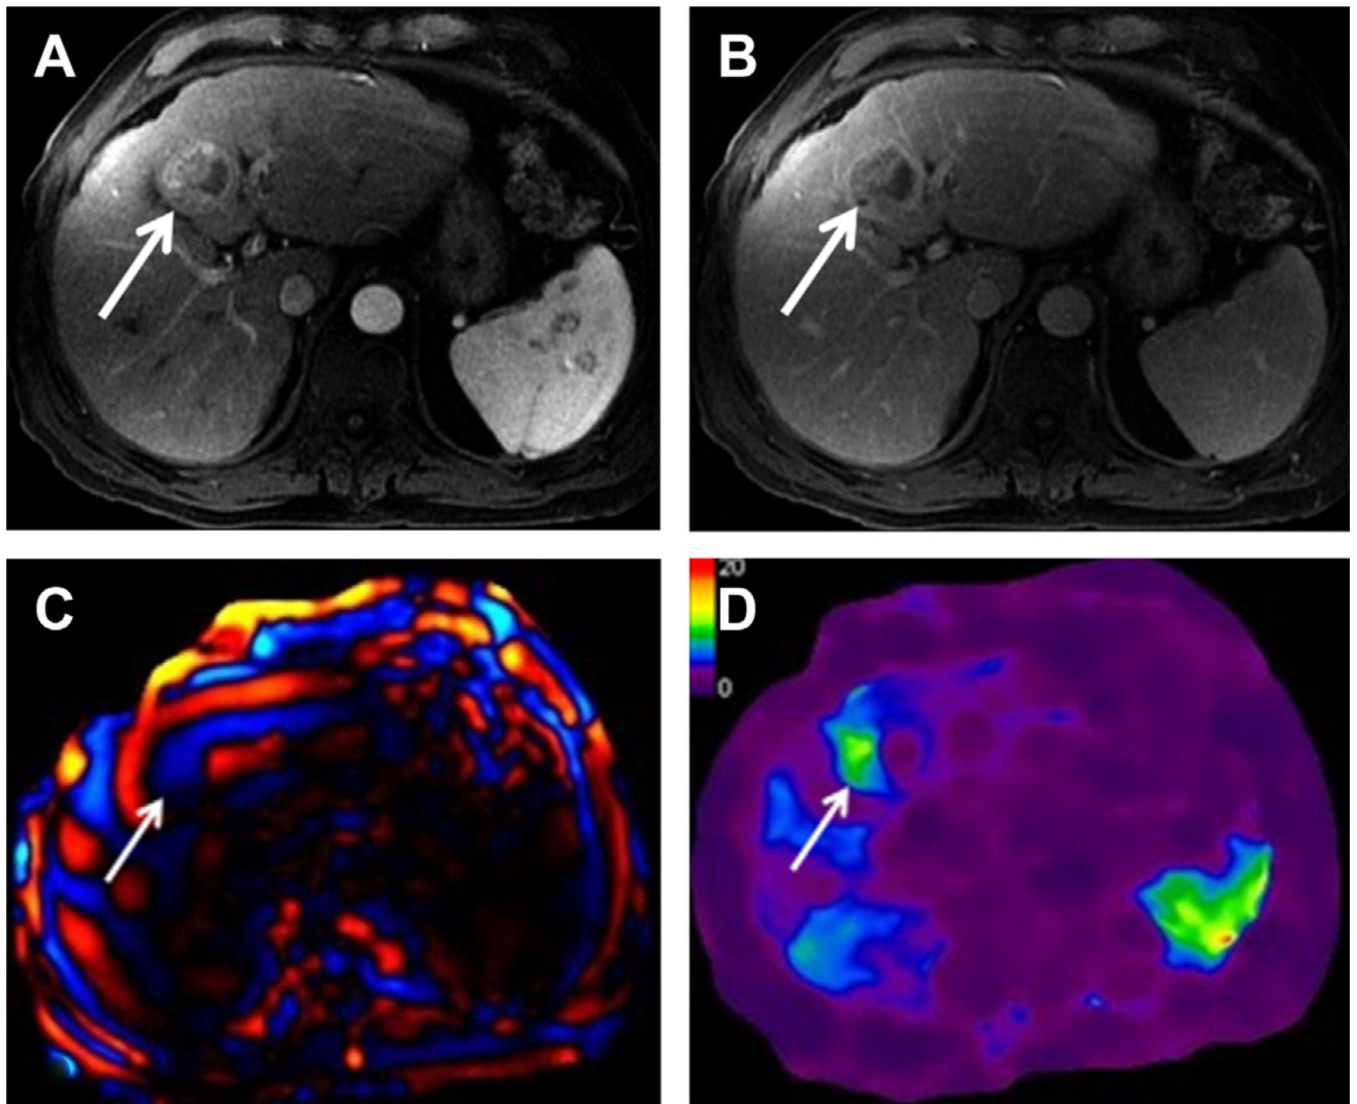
MRE of HCC (*arrows*). (*A, B*) DCE-MR imaging during the arterial and venous phases shows a nodule with the typical pattern of wash-in/washout. (*C, D*) Wave and elastogram maps demonstrate increased stiffness of the lesion with a value of 8.33 kPa, consistent with a malignant origin. (*Courtesy of Alvin C. Silva, MD, Mayo Clinic, Scottsdale, AZ.*)
